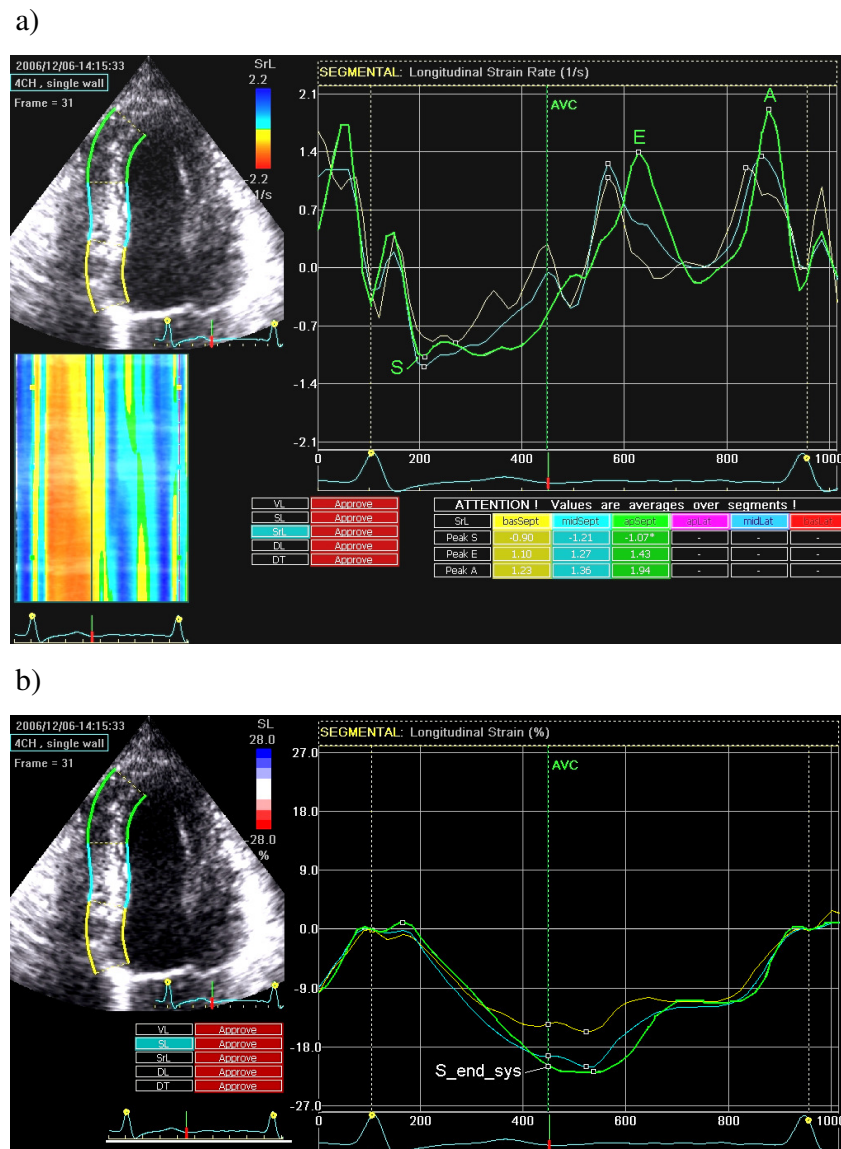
+b: Typical strain rate and strain profiles of a healthy subject derived from tissue Doppler imaging and explanation of measurements. a) 1: systolic peak strain rate (SR<sub>S</sub>); 2: peak strain rate in isovolumetric contraction time (SR<sub>IVCT</sub>); 3: peak strain rate in isovolumetric relaxation time (SR<sub>IVRT</sub>); 4: early diastolic strain rate (SR<sub>E</sub>); 5: late diastolic strain rate (SR<sub>A</sub>); 6: maximal strain in one cardiac cycle (S<sub>max\_cyc</sub>); b) 7: maximal strain in ejection phase (S<sub>max\_sys</sub>); 8: end systolic strain (S<sub>end\_sys</sub>); 9: post systolic shortening (PSS); 10: shortening duration of PSS.
